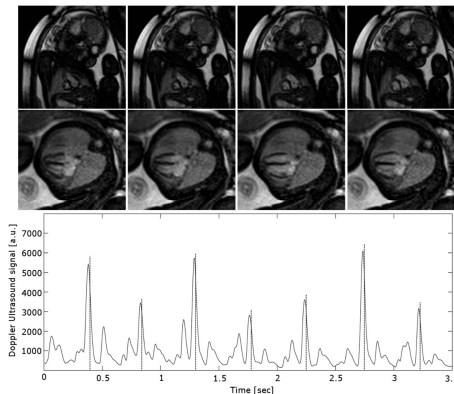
Short axis images of end- and mid-systole and diastole in the upper row and in the four chamber view below respectively. Shown at the bottom is the acquired Doppler ultrasound signal during MRI acquisition and the corresponding trigger signal outputs.
